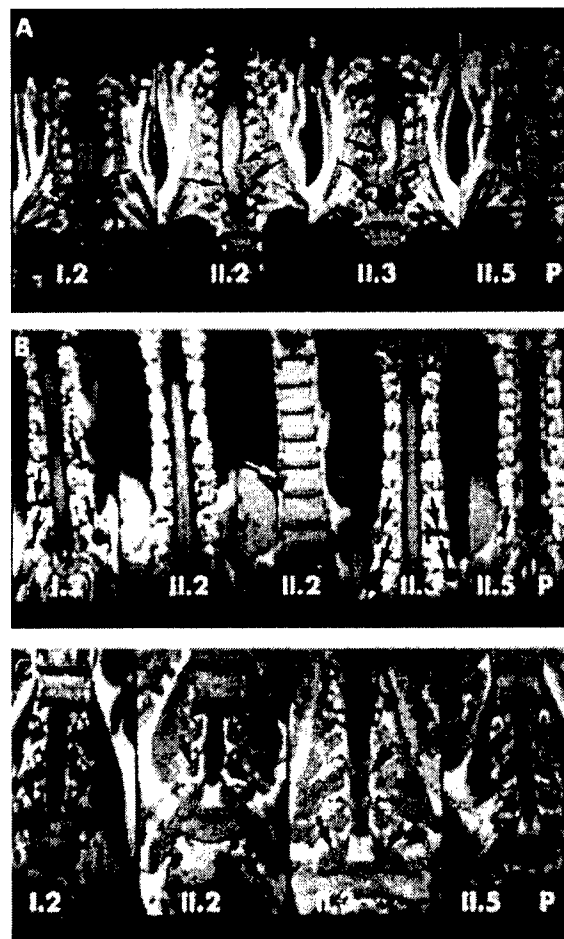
Coronal T1 weighted non-contrast MR images (Siemens Magnetom 1.0T, SE, TR 500, TE 15, slice thickness 3 mm) of patients I.2, II.2, II.3, and II.5 (P-proband) from family 2, carrying the mutation L357P. (A) Cervical spine. (B) Thoracic spine. (C) Lumbar spine. Several extradural, intraspinal neurofibromas compressing the spinal cord (black curved arrows) and extraspinal neurofibromas (black straight arrows) are seen in all patients. Not all tumours are marked. II.2 also has a right sided paraspinal thoracic mass (white arrow). The intra- and extraspinal components of a dumb-bell tumour in the lumbar spine (thick black arrow) in patient II.3 are shown.
